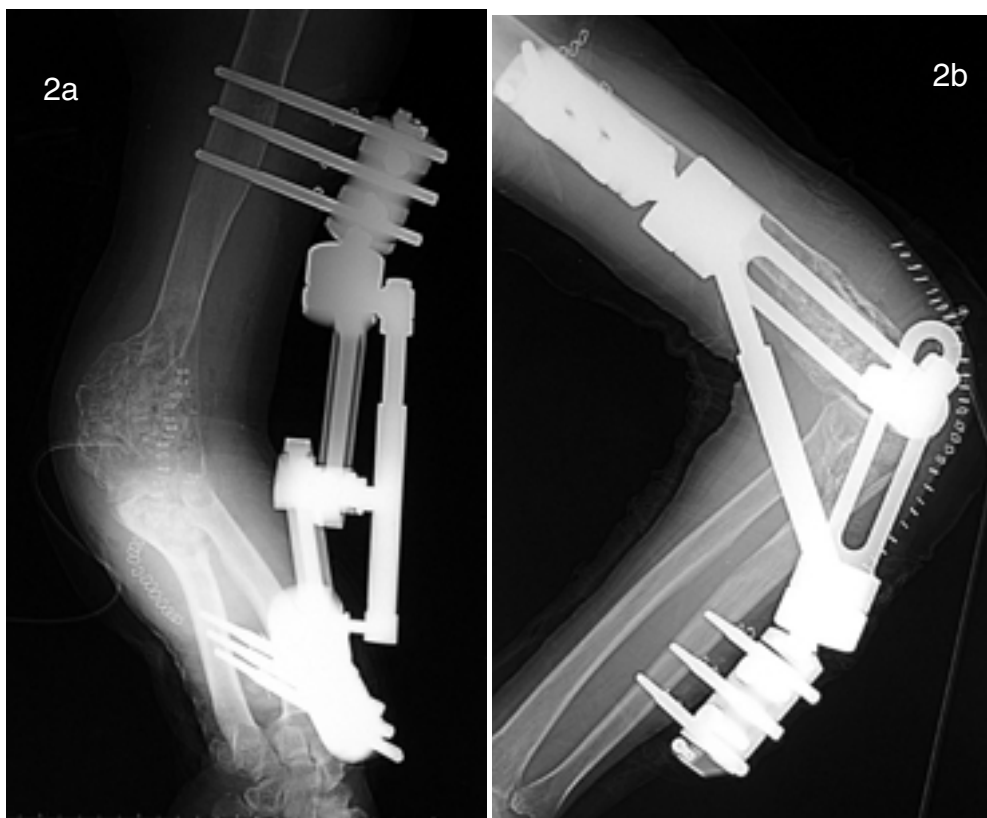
Post operative plain radiographs of the left elbow. An external fixator was used for postoperative fixation (a: anterior oblique view; b: lateral view).
